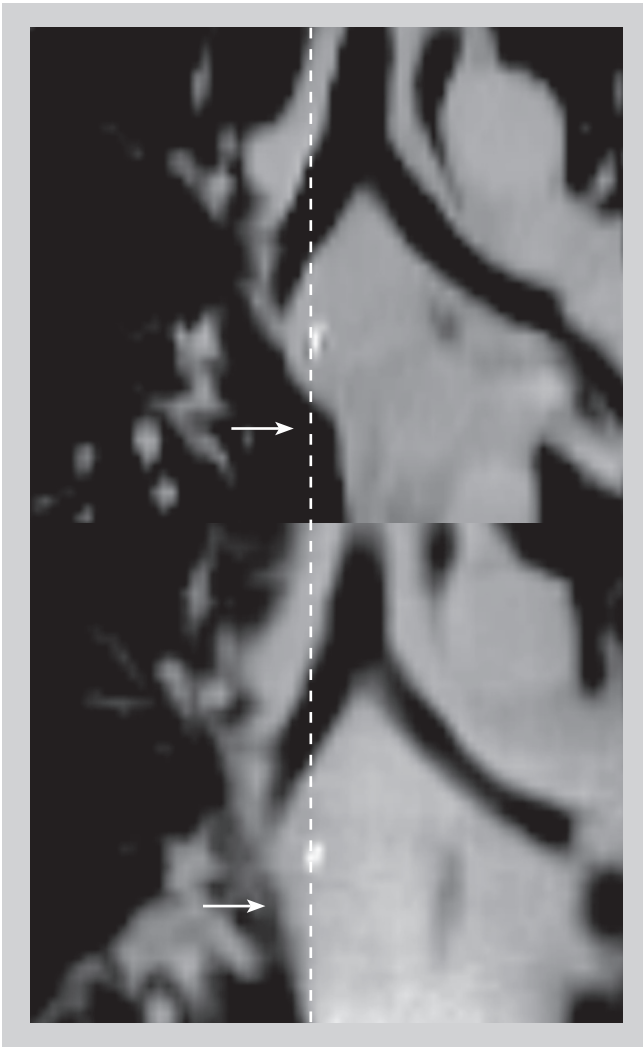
Coronal view of the planning CT scan and CBCT scan of the last fraction for the patient for which accurate local rigid soft tissue registration was not feasible due to substantial anatomical changes at the mediastinal-lung interface.
